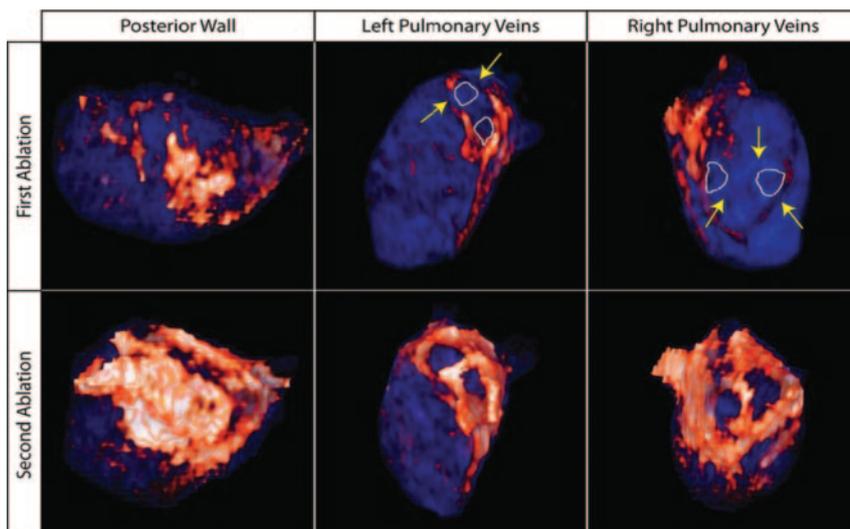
Three-dimensional MRI model of the LA after failed PVA isolation (First) and repeat successful PVA isolation (Second). After the initial failed ablation, all 4 PVs showed incomplete PVA scar as evident by lack of continuous scar (orange/white) around each pulmonary vein ostia (white outline). Gap lesions of healthy myocardium (blue) were identified and targeted (yellow arrows) before repeat ablation. After the successful repeat procedure, all 4 PVA had continuous scar lesions.
